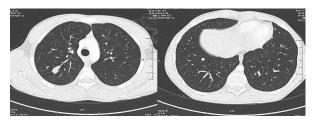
CT of the thorax with venous contrast - There are multiple lung metastases in the parenchyma of both lungs
